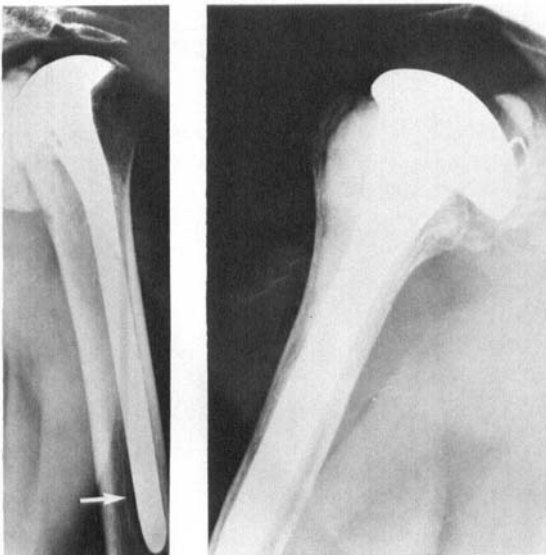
(left). Radiograph of the left shoulder of a 55-year-old man five years after hemi-arthroplasty. Resorption zone at the distal end of the shaft (arrow). The shoulder is painfree.
